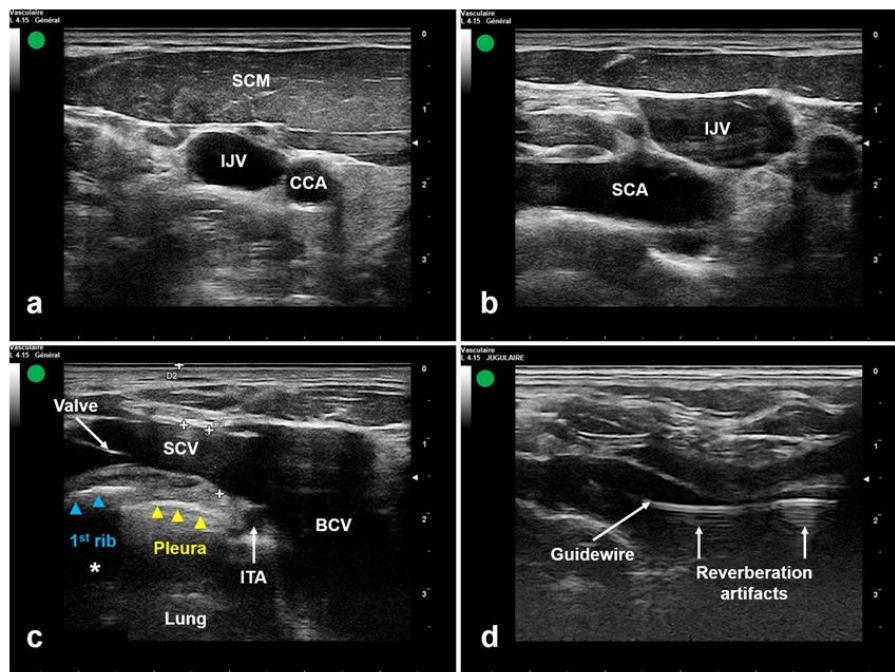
Ultrasound-guided subclavian vein catheterization utilising the supraclavicular approach and in-plane needle. An IJV ultrasound short-axis image. b Supraclavicular fossa ultrasound detection of IJV and SCA. SCV/BCV ultrasound long-axis view. SCV ultrasound guidewire visualisation. SCA subclavian artery, BCV
